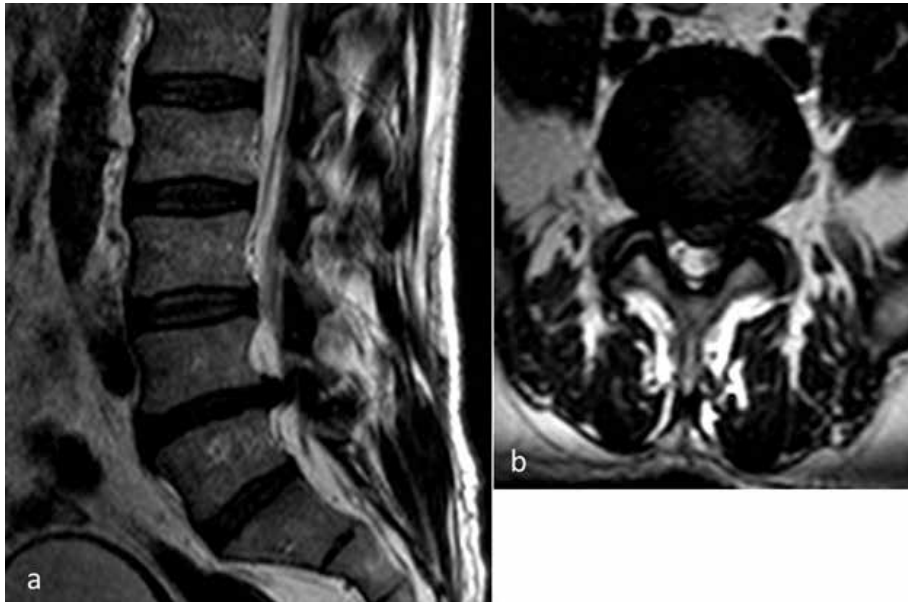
A left L4-5 lumbar disc herniation with a wide basis was seen on the T2-weighted sagittal (a) and axial (b) MRI sections before percutaneous hydrogel implantation.
